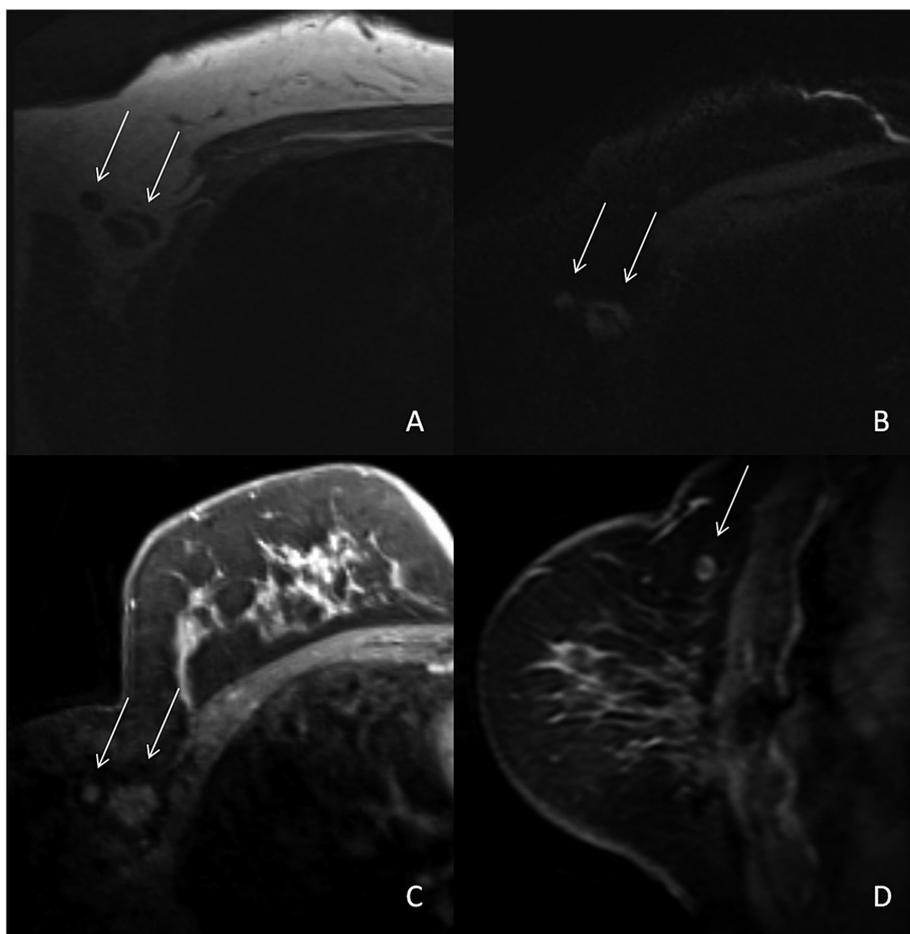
Lymph nodes classified as “positive” at contrast enhanced 1.5T MRI due to short axis ≥ 5 mm, no discernible hilum, irregular margins, inhomogeneous cortex and contrast enhancement. A) T1-weighted TSE sequence; B) T2-weighted TIRM sequences; C) 3D T1-weighted FLASH after contrast injection; D) sagittal fat-saturated T1-weighted FSE sequence after contrast injection.
